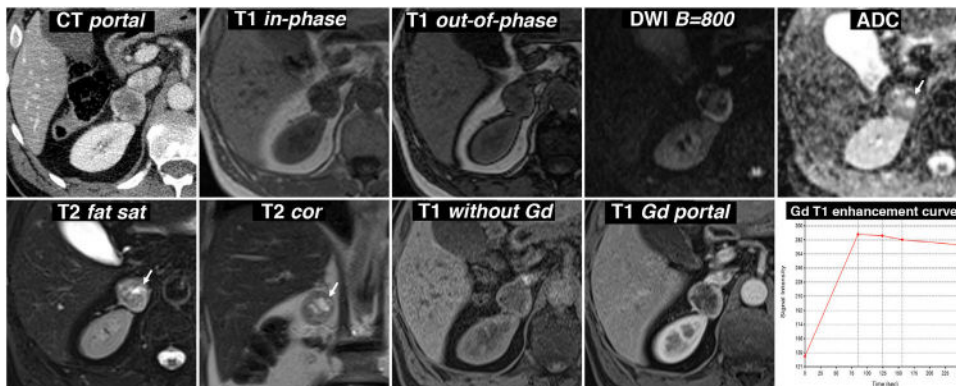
Incidental finding of adrenal pheochromocytoma with cystic areas while being investigated due to abdominal trauma. 57-year-old male. Portal phase CT incidentally identifies a right adrenal nodular lesion with a more hypoattenuating centre and a hyperattenuating periphery, probably due to contrast enhancement. On the MRI, there is no signal drop out-of-phase. It is markedly hyperintense on T2-weighted images, with some cystic-like foci (arrows), which show high signal on the ADC map due to the absence of restriction of water diffusion. These foci therefore lose the signal in the diffusion-weighted sequence with a high B value. In the dynamic study, with contrast, the periphery of the lesion shows intense enhancement, with the peak in the arterial phase of the study, while the centre, with cystic phenomena demonstrated by pathology examination, has little enhancement.
